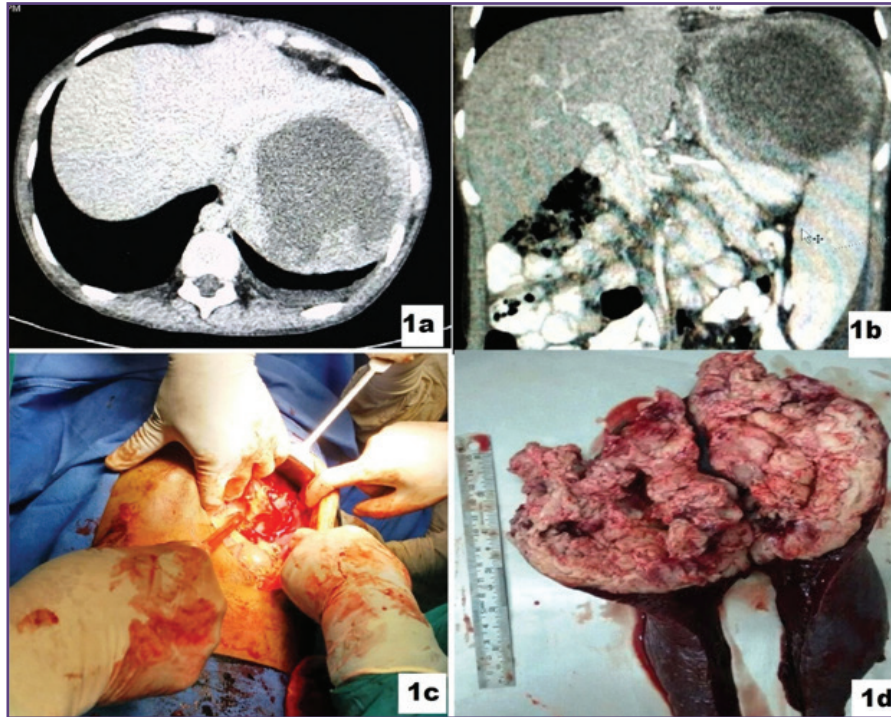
Computed tomography showing massive splenomegaly (axial section); 1b- Computed tomography showing massive splenomegaly (coronal section); 1c- Per operative photo showing ligation of splenic hilum; 1d- Cut Section shows single large grayish white lesion with abundant central necrosis and a rim of normal splenic parenchyma at the periphery.
